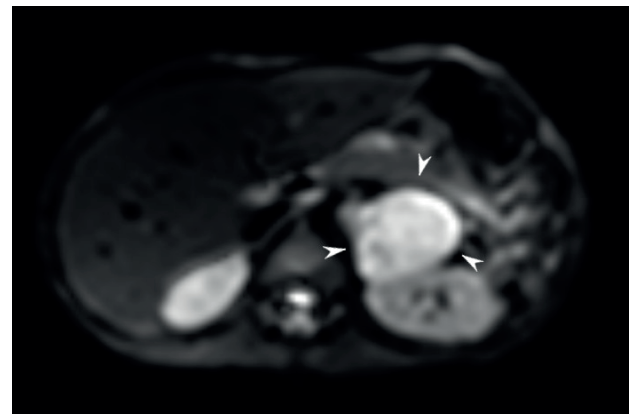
Trace diffusion-weighted transverse MRI shows a large hyperintense mass in the left adrenal tract (arrowheads).
